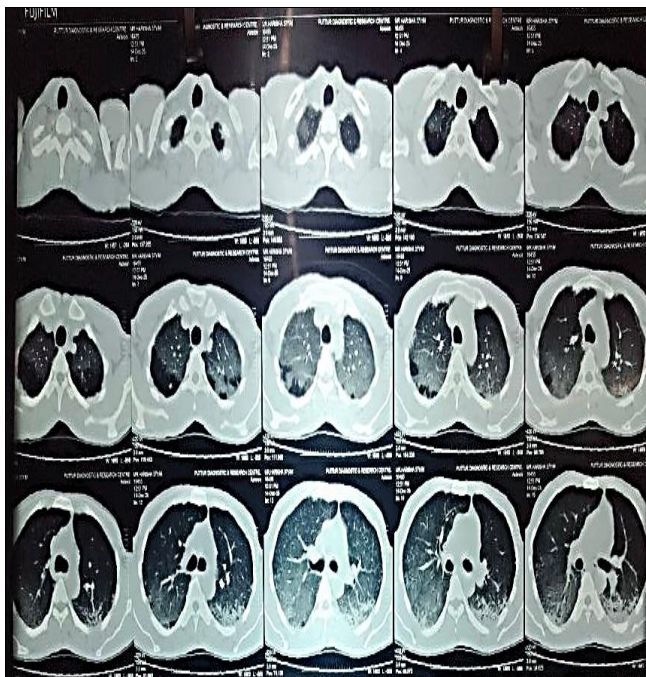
HRCT thorax showing extensive bilateral ground-glass opacities with basal predominance and areas of consolidation
